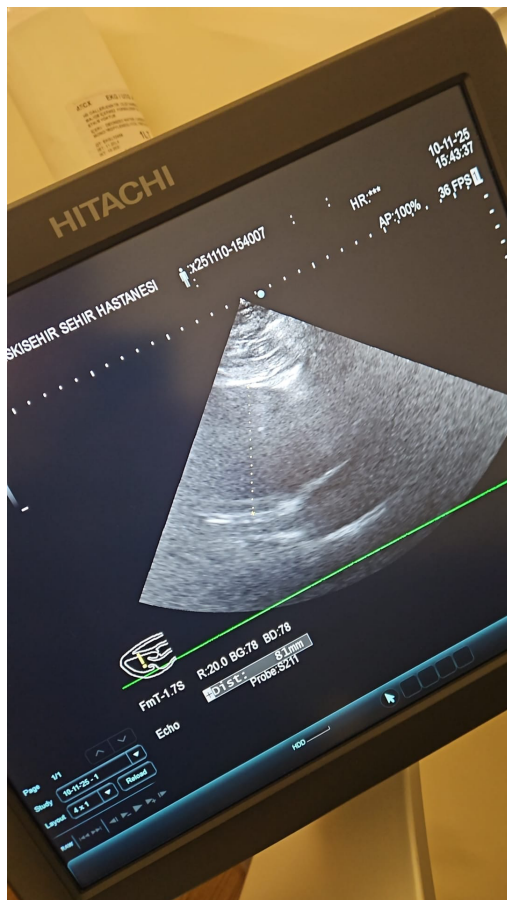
Echocardiography shows an ascending aorta measuring 81 mm.
